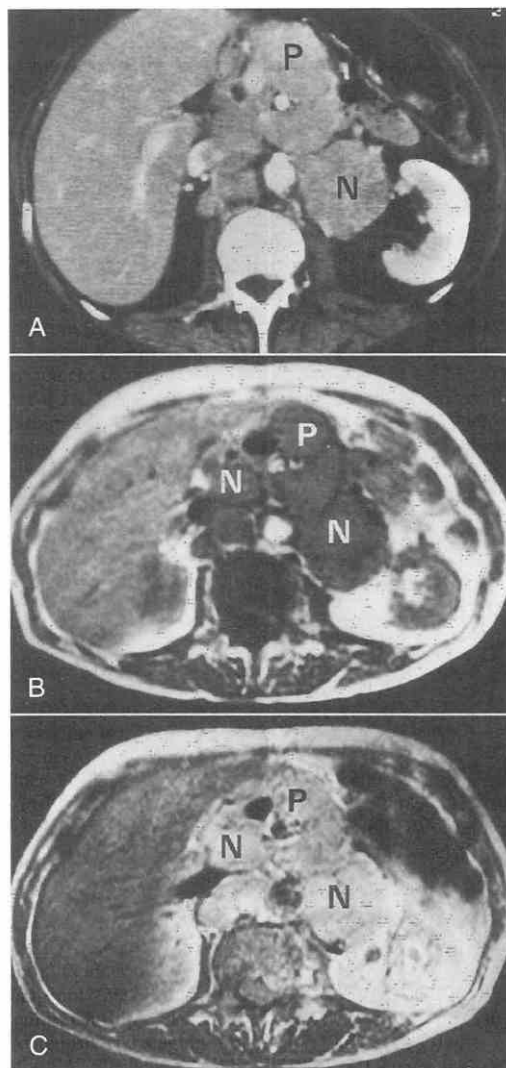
A 55-year-old woman with multiple endocrine neoplasia type I and Zollinger-Ellison syndrome for 18 years exhibits a tumor of the body of the pancreas with lymph node and bone metastases. A, CT scan after intravenous contrast administration demonstrates enlargement of the body of the pancreas (P) and lymph node metastases (N) that are isodense. B, T1-weighted (SE, TR = 300 msec, TE = 20 msec) MR image shows the pancreatic tumor (P) and the lymph node metastases (N) with a homogeneous low signal intensity compared with that of the normal liver parenchyma. The sharply delineated contours of the multiple lesions are readily visible. C, T2-weighted (SE, TR = 2000 msec, TE = 50 msec) MR image reveals the slightly inhomogeneous high signal intensity of the pancreatic tumor (P) and lymph node metastases (N). (From Tham RTOTA, Falke THM, Jansen JBM, Lamers CBHW: CT and MR imaging of advanced Zollinger-Ellison syndrome. J Comput Assist Tomogr 13:821-828, 1989.)
